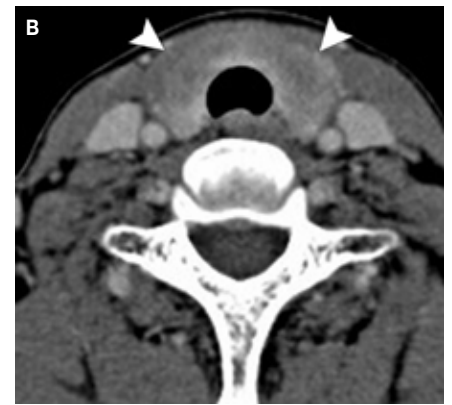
IgG4-related thyroiditis: Axial unenhanced (A) and contrast-enhanced (B) CT scans demonstrate diffuse low attenuation of the thyroid gland with poor enhancement (arrowheads).
